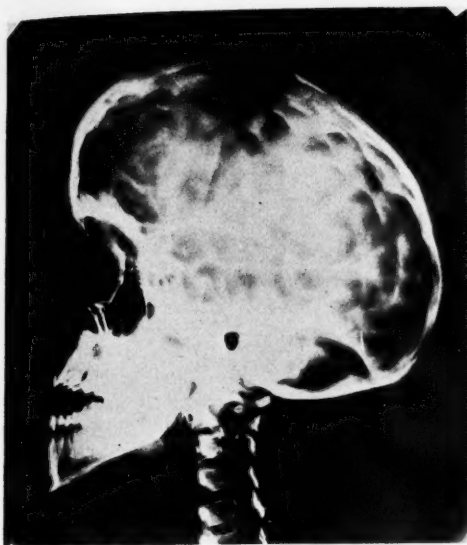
X-ray No. 37,448. Girl, age 17. *Complaint:* Headaches and dizziness. Blind for 11 years. *P. E. shows* primary optic atrophy. *Operation:* Decompression. *X-ray shows* synostosis cranii with signs of marked intracranial pressure.
